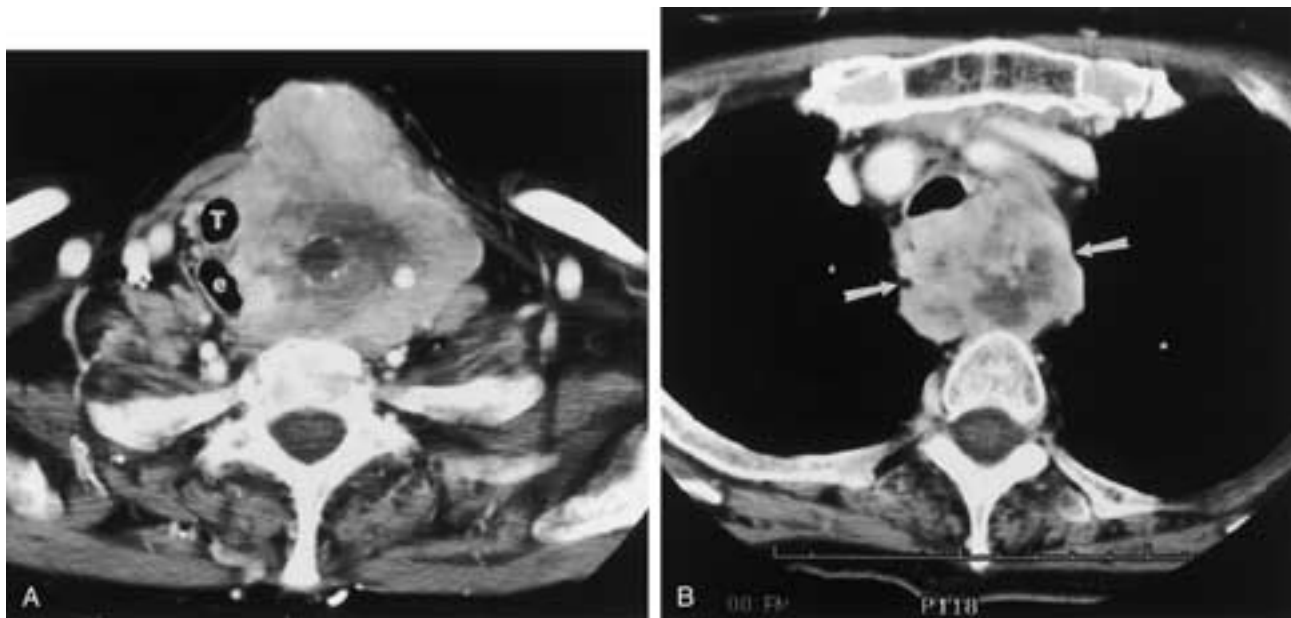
Enhanced CT scan of a multinodular goiter with substernal extension and compression of the trachea and esophagus. A, Axial CT scan at the level of the upper trachea shows diffuse nodular enlargement of the thyroid gland that is heterogeneous in density. There is marked displacement of the trachea (*T*) and esophagus (*e*) from left to right. B, There is extension of goiter (*arrows*) behind the trachea into the middle mediastinum.
